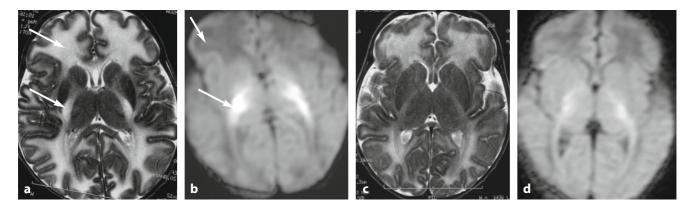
A baby with maple syrup urine disease showing at the first MR (a, b) severe abnormalities of the signal (*arrows*). On axial T2 scan (a) increased signal (*arrows*) in the frontal white matter and at the level of posterior limbs of internal capsule (PLIC) are observed. Interestingly the DWI scan (b) shows a completely different pathogenesis; PLIC are represented by a restriction signal on DWI, signs of reduced movements of water molecules, while in the frontal areas DWI shows an opposite signal (increased water molecules movement) very likely expression of vasogenic oedema. c, d A week after renal dyalisis performed to reduce the amount of the toxic levels of leucine a dramatic improvement of the signal abnormalities is observed
